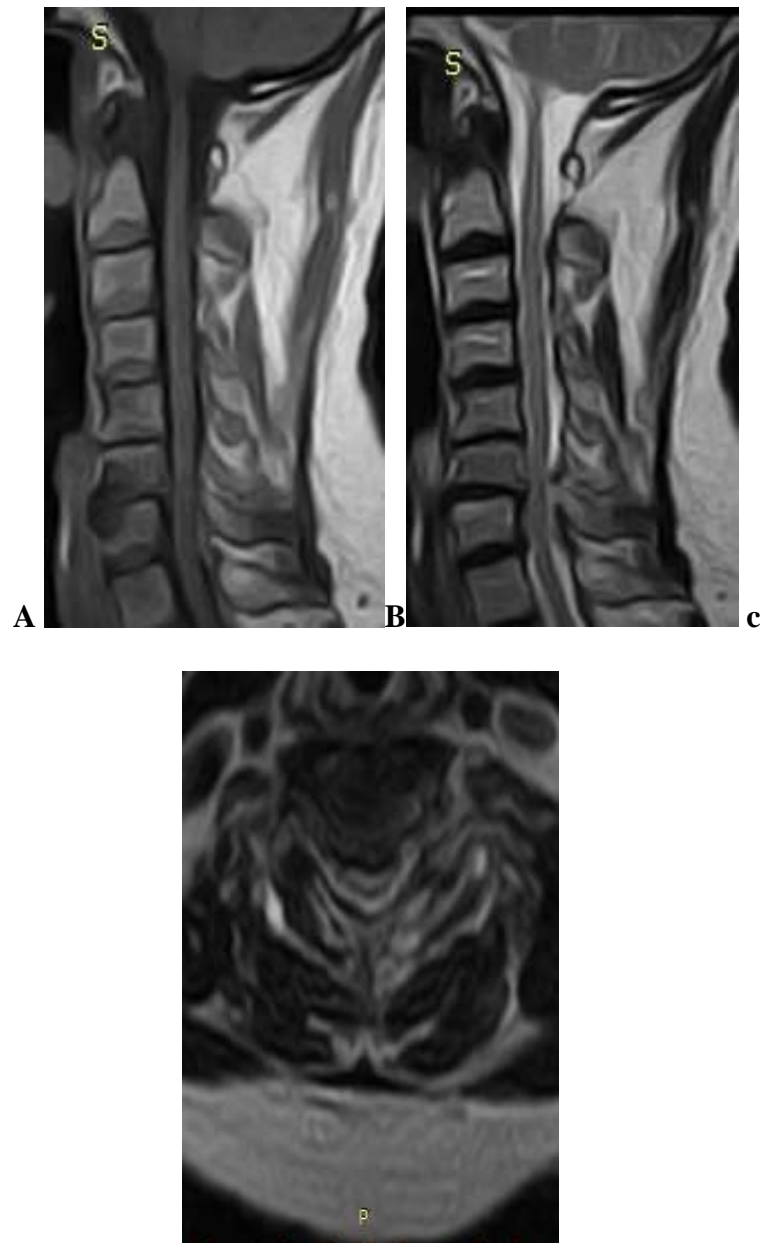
T2WI cervical spine MRI of a 59-year-old woman who presented with 1-year history of intermittent neck pain, upper limbs weakness, and numbness of both hands. A. The image on mid-sagittal plane revealed cervical spondylosis at C3/4, C4/5 and C5/6 causing effacement of the surrounding CSF in the subarachnoid space and varying degree of spinal cord compression. Maximum cord compression associated with increased spinal cord T2 signal intensity was observed at C4/5. B. On axial plane at the C4-5 level showed spinal cord deformity and flattening caused by a bulging disc and osteophytic spurring anteriorly associated with spinal cord T2 signal hyperintensity.
